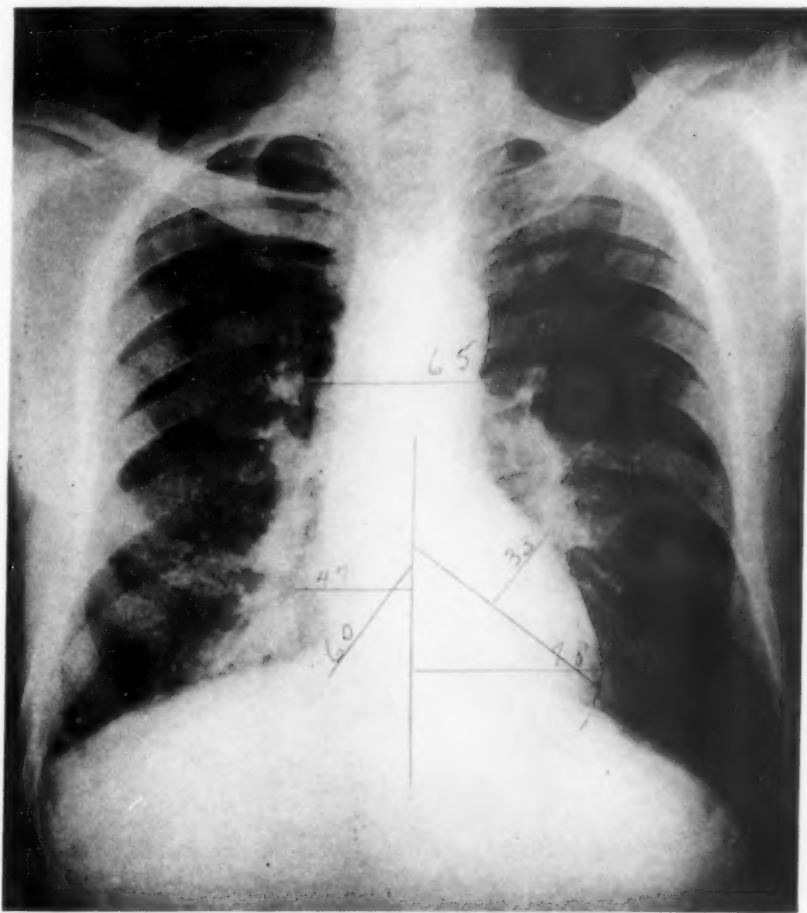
Roentgenograph of chest of S. B., January 1934, made during a period of freedom from infection. Nodular fibrosis has become more distinct.
